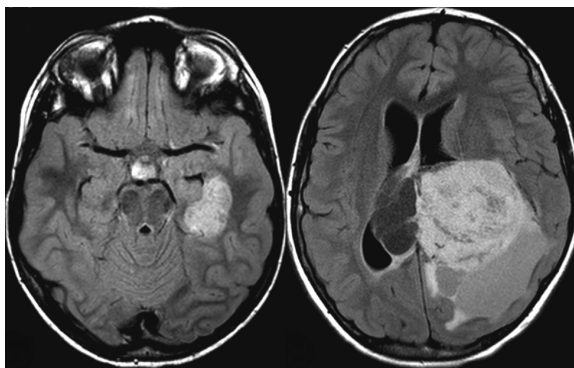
Representative FLAIR MR images from the target dataset. White regions in the image correspond to tumorous regions of the brain and contribute to the patient’s LGG.
